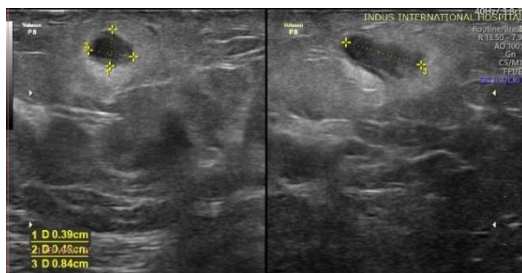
Ultrasound image shows well defined rounded hypoechoic cyst like lesion measuring approximately 3.9x4.9x8.4 mm noted in the upper outer quadrant in superficial planes with surrounding raised echogenicity of breast parenchyma and fat- s/o inflammatory changes. Internal moving low-level echoes seen
